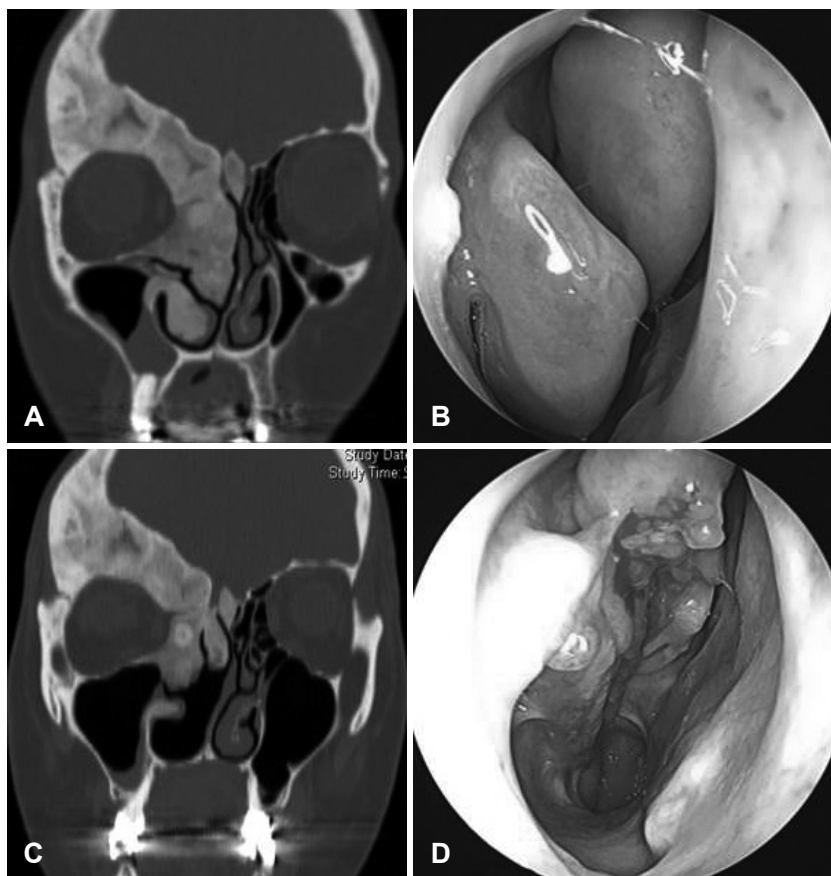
Pre-operative CT image of the patient. Fibrous dysplasia invading inferior, middle turbinates and frontal bone was noted (A). Pre-operative endoscopic findings in the patient. The enlarged inferior middle turbinate was nearly obstructed in the right nasal cavity, and the septum was deviated to the contralateral side (B). Post-operative CT image of the patient. Partial resection of the right inferior middle turbinates and conservative septoplasty were performed (C). Post-operative endoscopic findings in the patient. The right nasal cavity was widened, and the overlying mucosa was well preserved (D).
